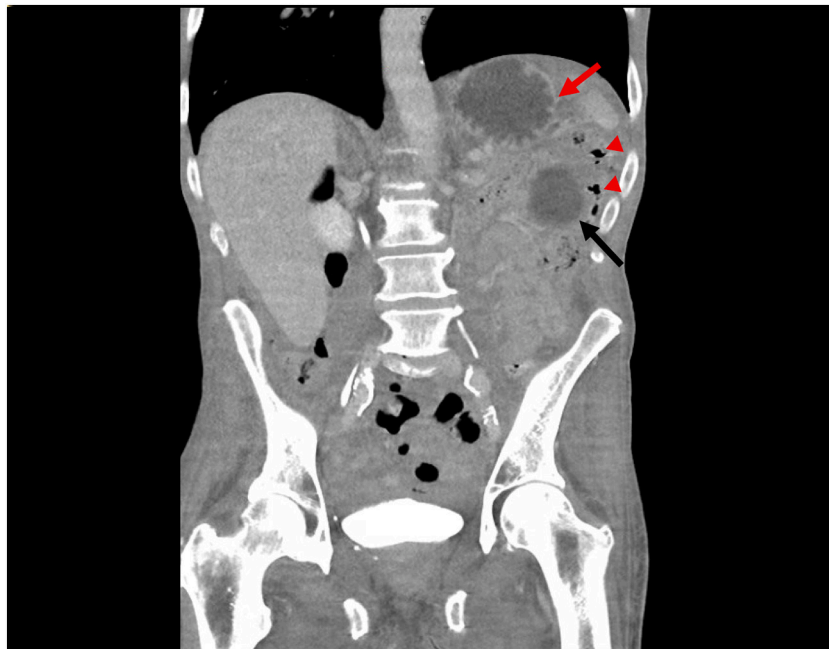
CT scan of the abdomen and pelvis reveals extra-luminal contrast (black arrow) with adjacent decompressed stomach (red arrow) and associated pneumoperitoneum (arrowheads).
